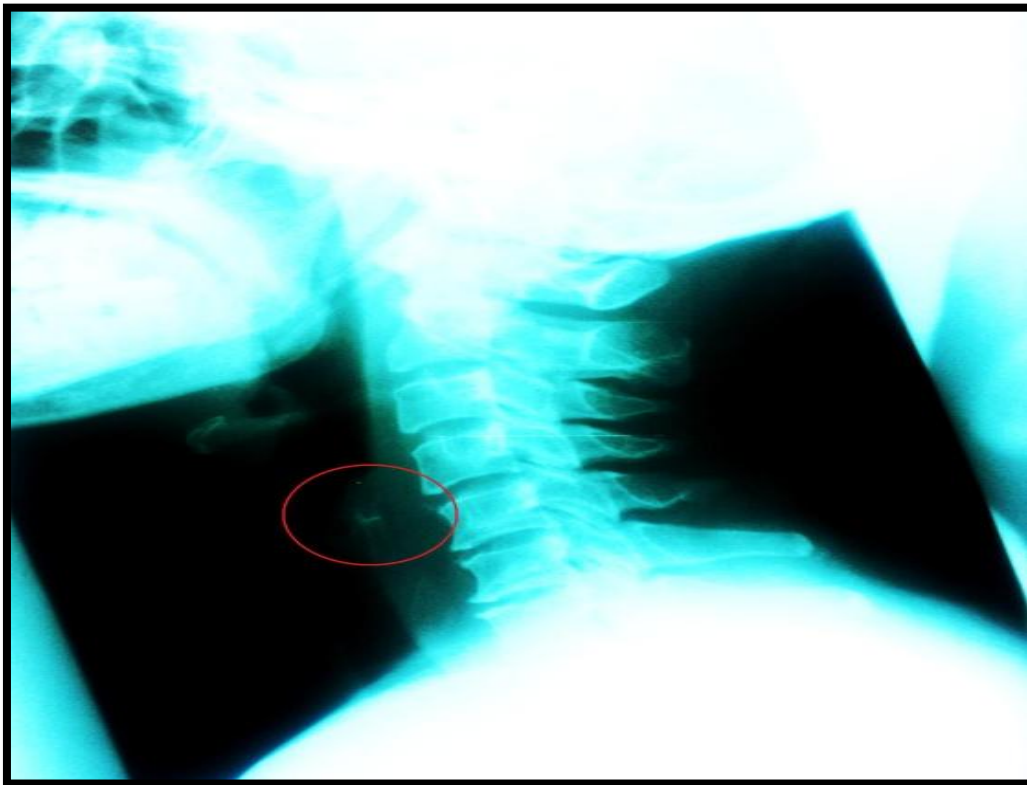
Neck radiography showed a longitudinal foreign body at the level of C6 - C7
